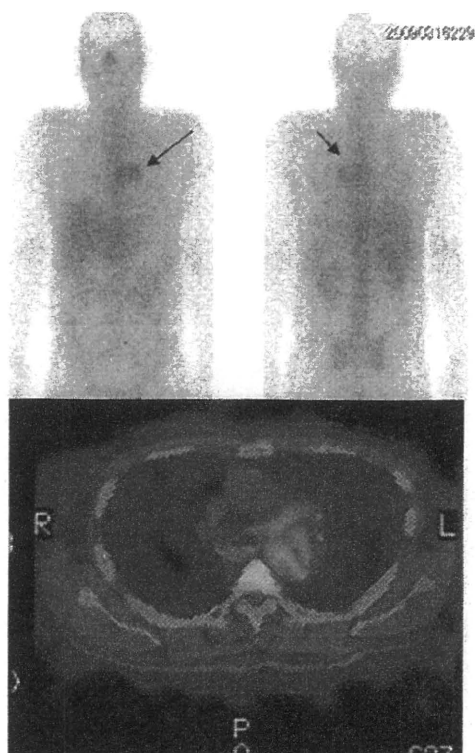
Ga-67 and CT fusion imaging. A. Ga-67 image shows abnormal accumulation at the upper mediastinum. (black arrow) B. Ga-67 SPECT and CT (Fig. 2A) fusion image of the infected aorta (red region).
